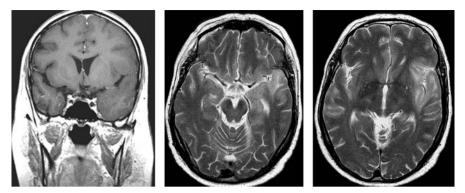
Very diffuse fronto-temporo-insular fibrillary astrocytoma with a history of intractable seizures. In T1 there is only a moderate mass effect in the left temporal lobe whereas the FLAIR images show the true extent of the tumor
